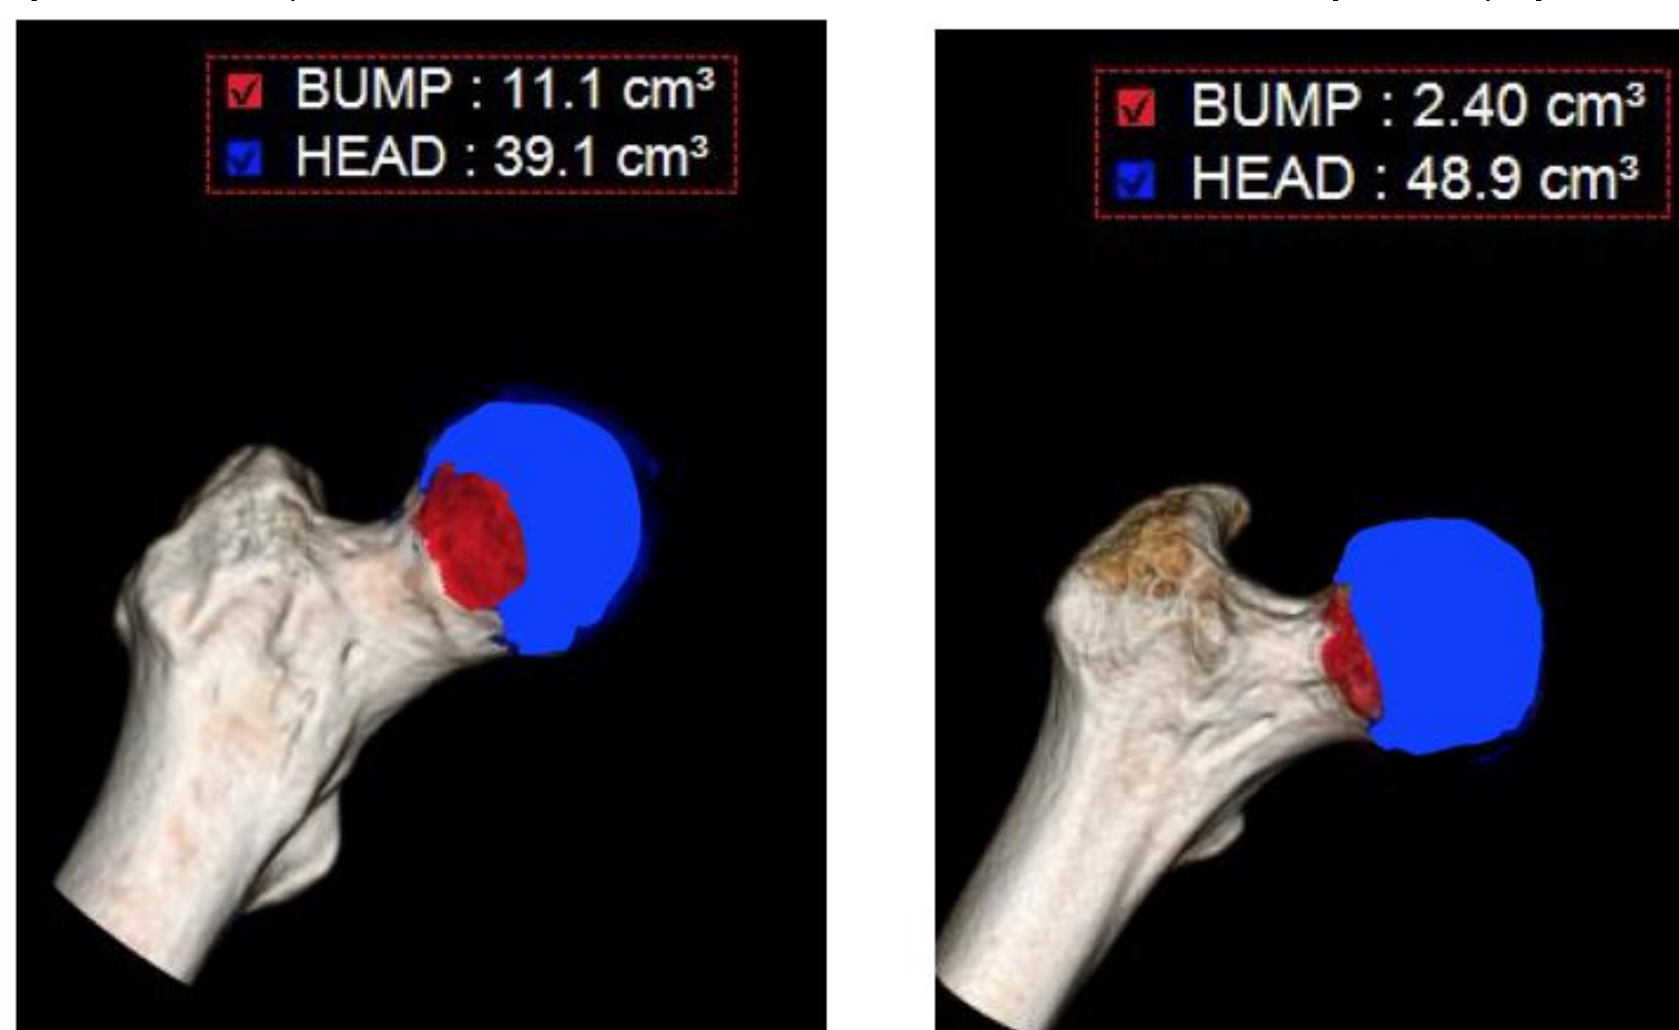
Image evaluation: Two readers independently performed all the measurements after performing 6 scans together for training. The case-control data was anonymized, and the readers were blinded to the patients’ history and laterality of symptoms. The Alpha angles were measured on radial 3DCT reconstructions. A “clock face nomenclature” was used for mapping the femoral head-neck junction with the anterior location as 3 o’clock and the superior location as 12 o’clock. The alpha angle was determined by a line through the center of the femoral neck to the center of a best fit circle, and a line connecting the center of the circle to the point where the femoral head exited the boundary of the circle. The clock face was rotated from 12, to 1, to 2 and finally to 3 O’clock, on the axial view of the CT. Four long axis images, one for each hour, were obtained. It took an average of 20 minutes to obtain alpha angle measurements. Quantification of the femoral head-neck junctional “bump” and femoral head volumes were obtained utilizing the ‘region grow’ segmentation technique. First, the free region of interest semi-automated tool was employed to remove the rest of the pelvis and acetabulum from the femur. The femoral head was carefully isolated using the ‘region grow’ tool and assigned a unique density based color region, avoiding the adjacent femoral neck. The volume tool was used to calculate the volumes of the head and bump. It took an average of 10 minutes to obtain head and bump segmentations and calculation of volumes.
